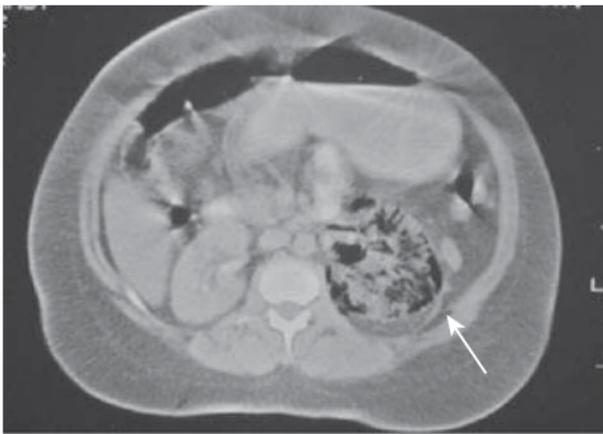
Enhanced axial CT scan demonstrating emphysematous pyelonephritis (type I) affecting the left kidney.
